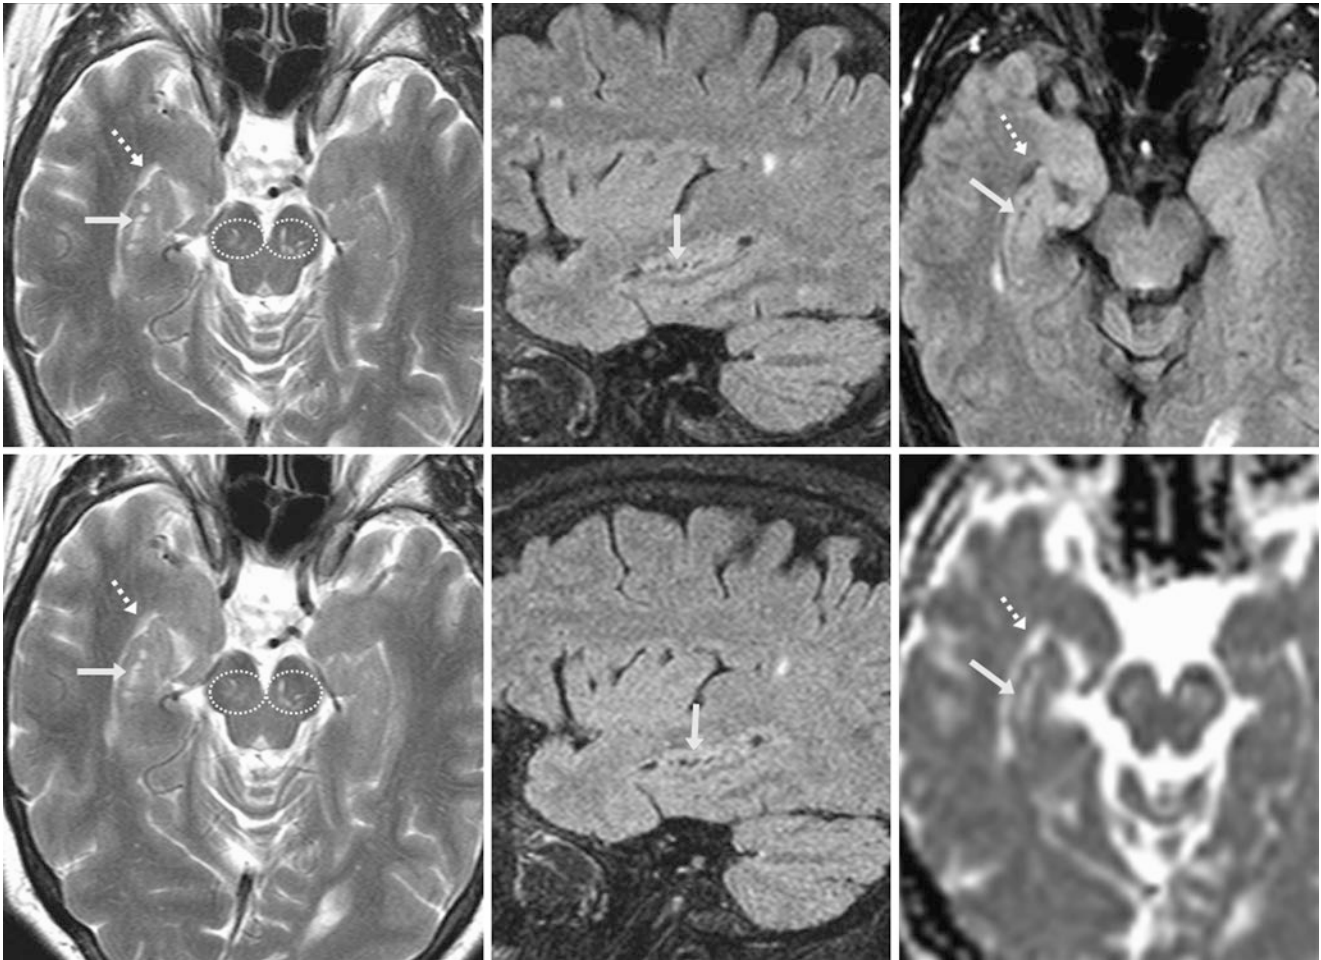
A 54 year old underwent an axial T2WI MRI (*top left*) that depicted multiple small hippocampal cysts (*arrows*) on the right side medial to the temporal horn (*dashed arrows*). Their appearance in the sagittal (*top middle*) and axial (*top right*) planes on FLAIR is also shown. There are also incidental dilated PVSS within the cerebral
